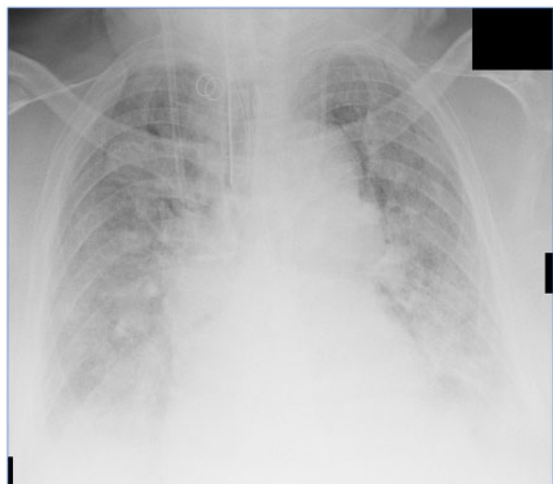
Chest X-ray showing bilateral consolidations as in acute respiratory distress syndrome as described in the text.
